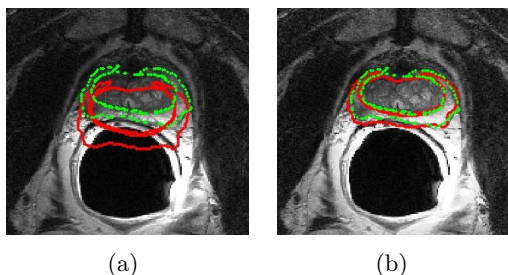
Manual prostate gland segmentation drawn on DWI (red) and T2 (green) superimposed on T2, before registration (a) and after registration (b)*
